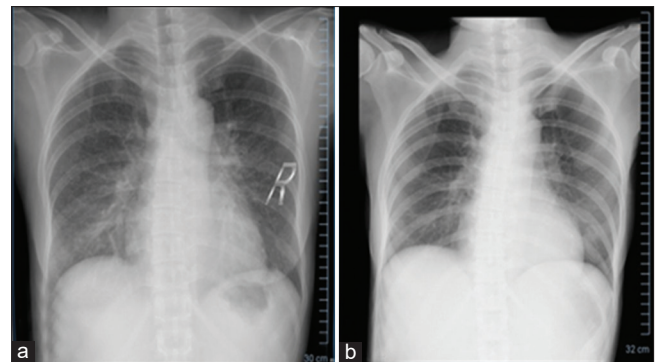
Chest X-ray of second patient, (a) 1st day of admission; (b) the last day of hospitalization
